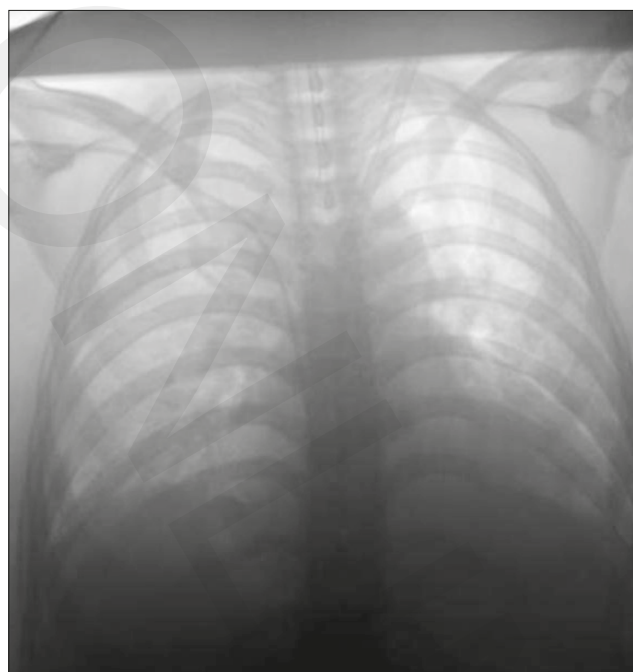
Lung changes observed during x-ray examination performed on the day of admission of the patient to hospital
